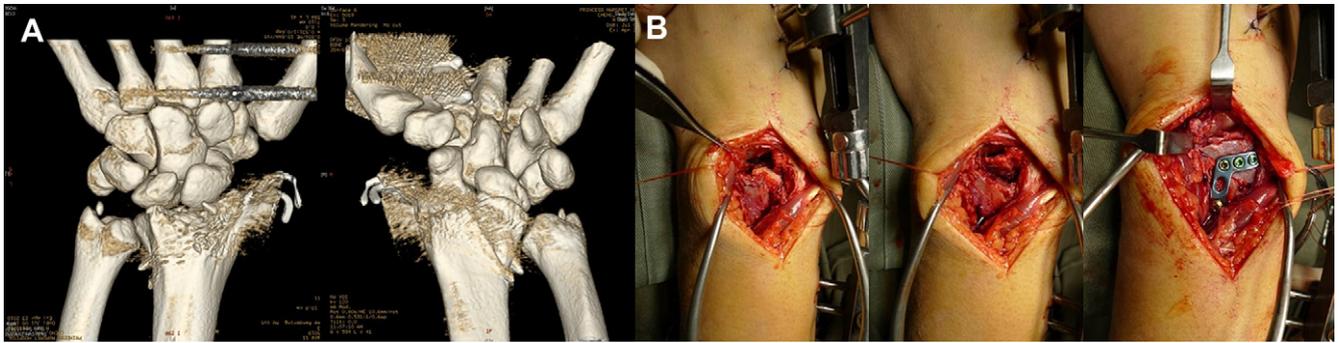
(A) Computed tomography scan showed an unreduced depressed dorsal articular rim fracture of left distal radius and a palmar die-punch fracture of distal radius at lunate fossa. (B) The depressed dorsal articular rim fracture of left distal radius was elevated and reduced. The corticocancellous graft was applied and fixed with buttress plate.
